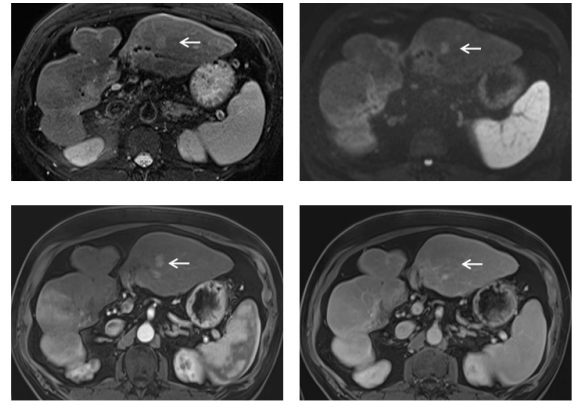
A 62-year-old male with HVC-related cirrhosis. Contrast-enhanced MR imaging was performed showing a 14 mm nodule (arrow) with signal hyper-intensity on T2-weighted images (A), signal hyper-intensity on diffusion (B), non-rim APHE (C), and no wash-out on portal venous or delayed phase images (D and E). The nodule was classified LR-4 on MR-imaging. Percutaneous biopsy was performed and showed a moderately-differentiated HCC nodule. The AFP level was abnormal (270 ng/ml).
